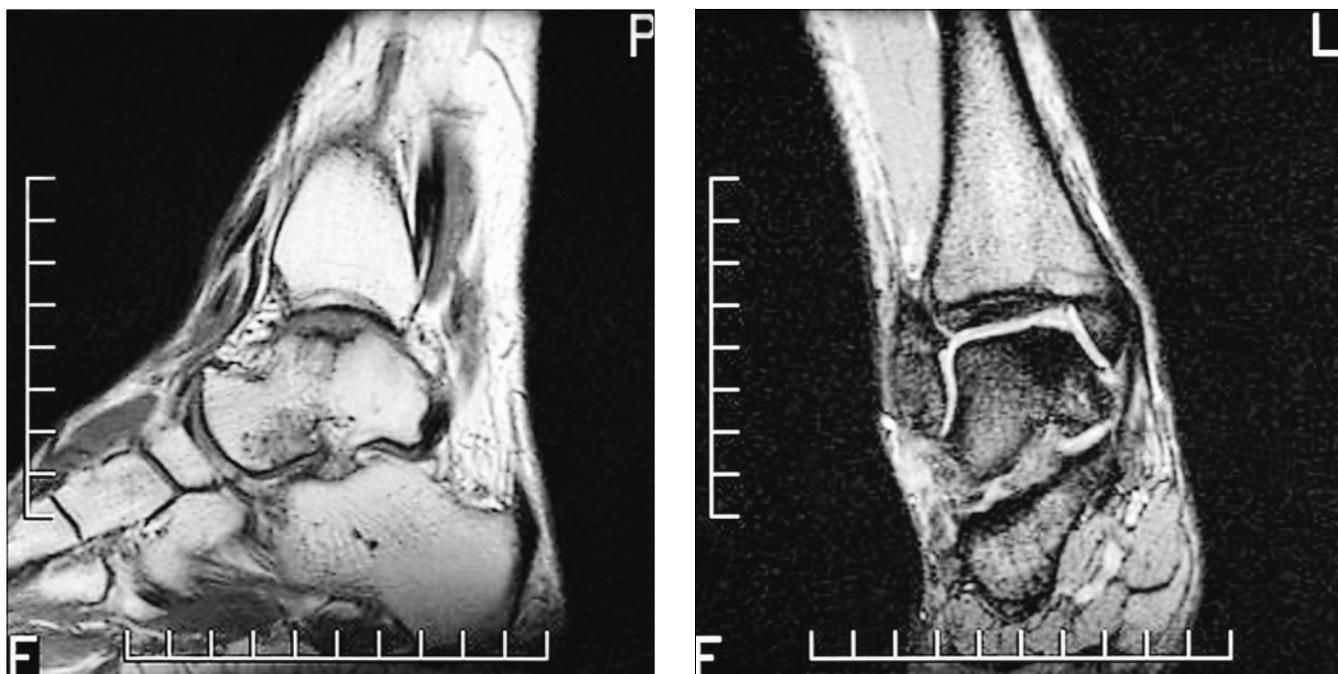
MRI 12 months after grafting shows that the articular irregularity has not progressed.
